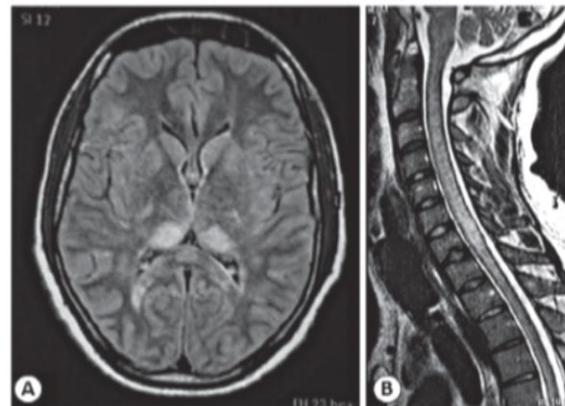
A: FLAIR MRI showing bilateral hyperintensity of the pulvinar nuclei of the thalamus. B: T2-weighted MRI showing diffuse hyperintensity throughout the spinal cord. FLAIR: fluid-attenuated inversion-recovery; MRI: magnetic resonance imaging.
